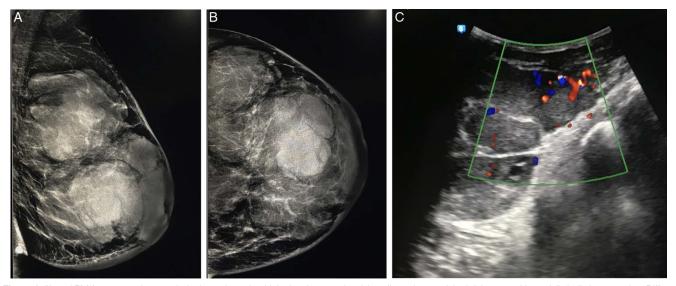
(A and B) Mammography revealed a large, irregular, high-density mass involving all quadrants of the left breast, with partially indistinct margins. Diffuse skin thickening was observed in the periareolar region and lower inner quadrant of the breast, but no internal calcifications were noted. (C) Ultrasound imaging revealed a large, irregular, heteroechoic mass with microlobulated margins and significant internal vascularity in the left breast.
